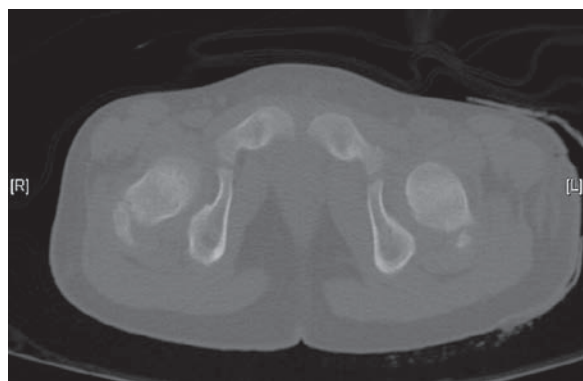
(continued) C: CT scan showing no anterior ring injury.
